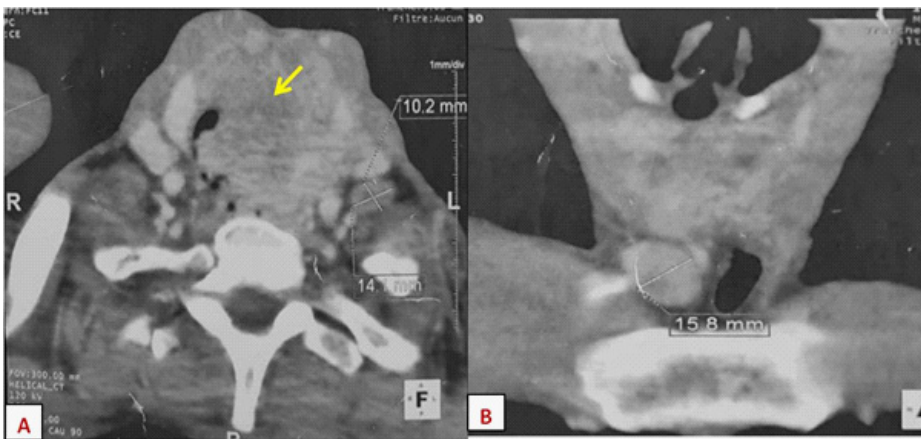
Axial (A) and Coronal (C) Cervical CT showing an enlarged thyroid gland exerting a mass effect on the trachea Right suprasternal adenomegaly with necrotic center.
